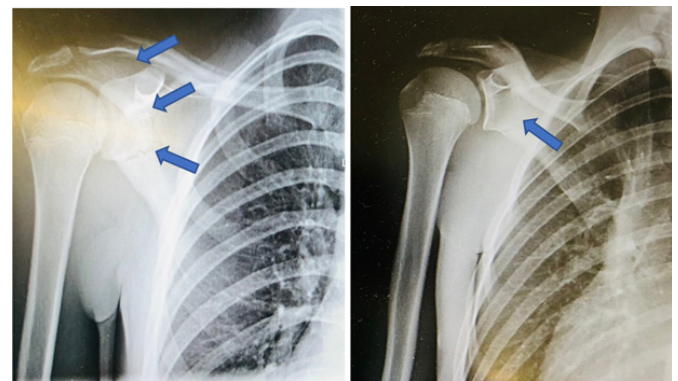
and 2 X-ray of right shoulder after fall (anteroposterior projection).
